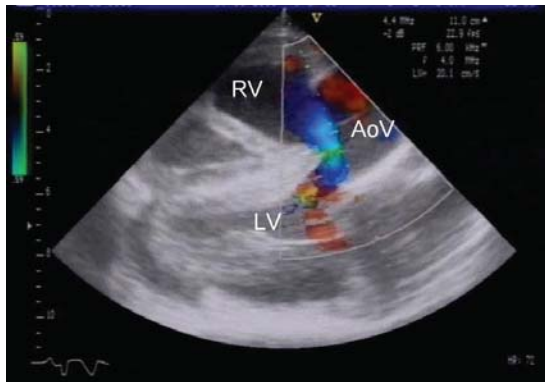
Right parasternal long-axis view - early diastolic right to left shunt (blue) through the ventricular septal defect between the 2 heart chambers. LV = left ventricle; RV = right ventricle; AoV = aortic valve.
